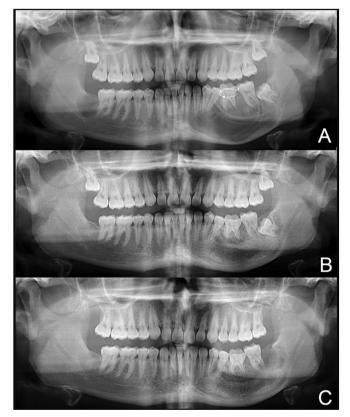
Sequence of panoramic panoramic radiographs. A) Radiography showing the two rigid drains apposed. B) X-ray after 8 months showing bone neoformation. C) Immediate postoperative radiograph of enucleation surgery and extraction of included teeth.
